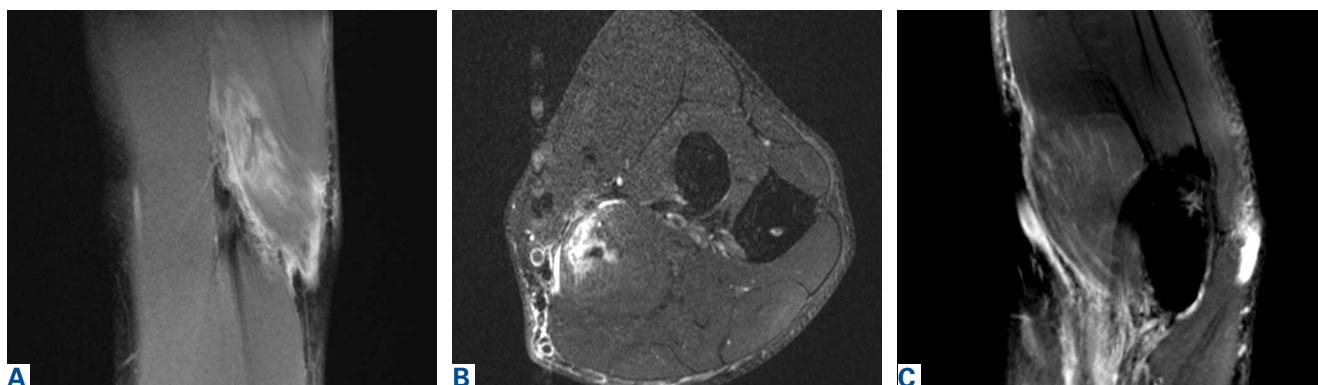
(A) Coronal T2-weighted magnetic resonance imaging (MRI) shows isolated edema of pronator teres and partial tearing of muscle belly near the myotendinous junction. (B) Axial T2-weighted MRI of proximal forearm shows edema of pronator teres muscle belly and fluid around the myotendinous zone of injury. (C) Sagittal T2-weighted MRI of the pronator teres injury.
